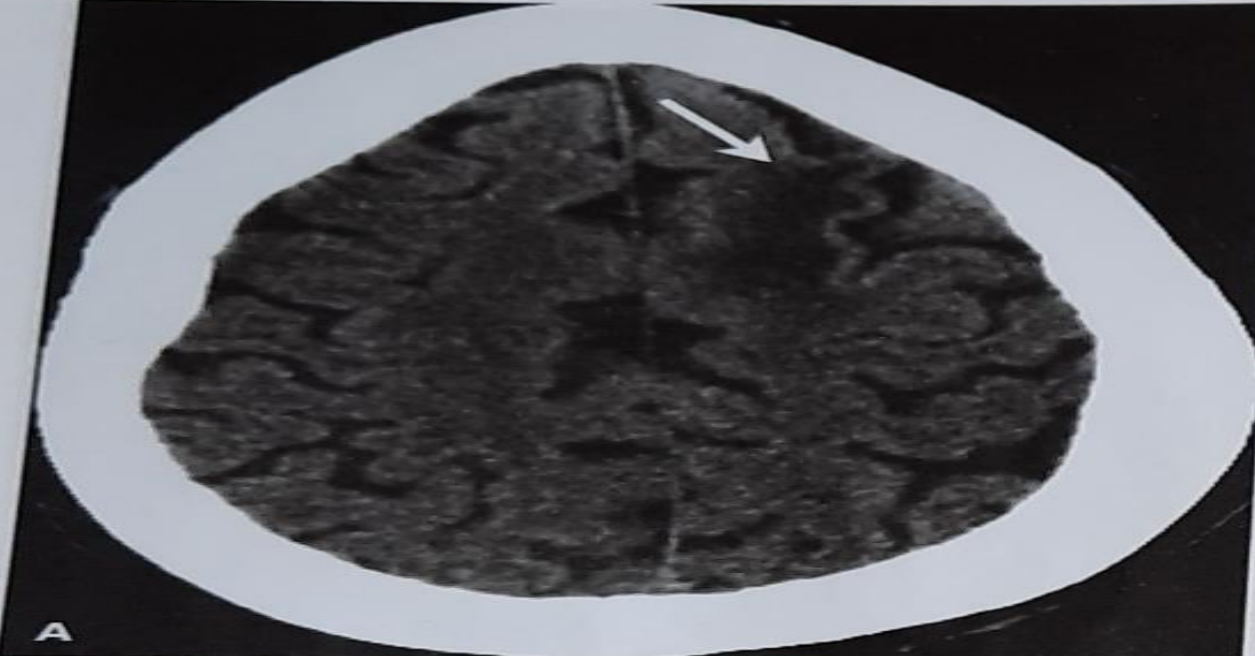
Axial CT scan (A) and T1-weighted (B) and T2-weighted (C) MRI scans of the brain. The CT scan (A) shows a hyperdense area in the right frontal lobe (white arrow). The T1-weighted MRI scan (B) shows a hyperintense area in the right frontal lobe (white arrow). The T2-weighted MRI scan (C) shows a hypointense area in the right frontal lobe (white arrow).
